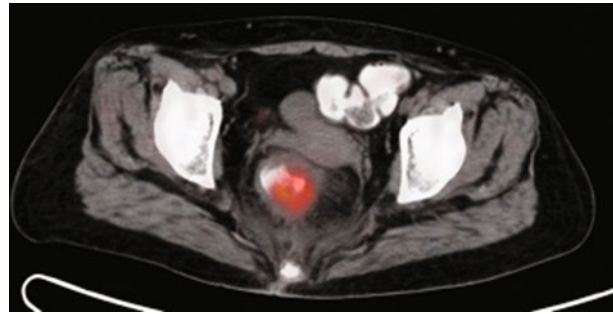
12 week PET/CT Scan of a rectal cancer patient treated with neoadjuvant chemoradiation. Metabolic active lesion at rectal wall suggesting incomplete response to therapy
